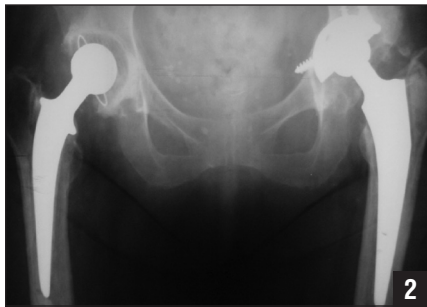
Preoperative anteroposterior radiograph of the pelvis with bilateral infected total hip arthroplasty, which was performed in Guatemala in a staged fashion 3 years prior to referral for infection.
